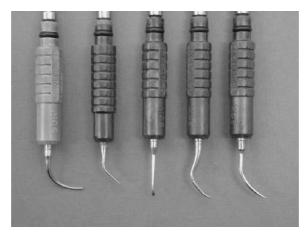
A selection of dental ultrasonic scalers including (L–R): Slimline, TFI-3, TFI-1, TFI-1000 and TFI-10 (courtesy of Dentsply, York, PA, USA).
